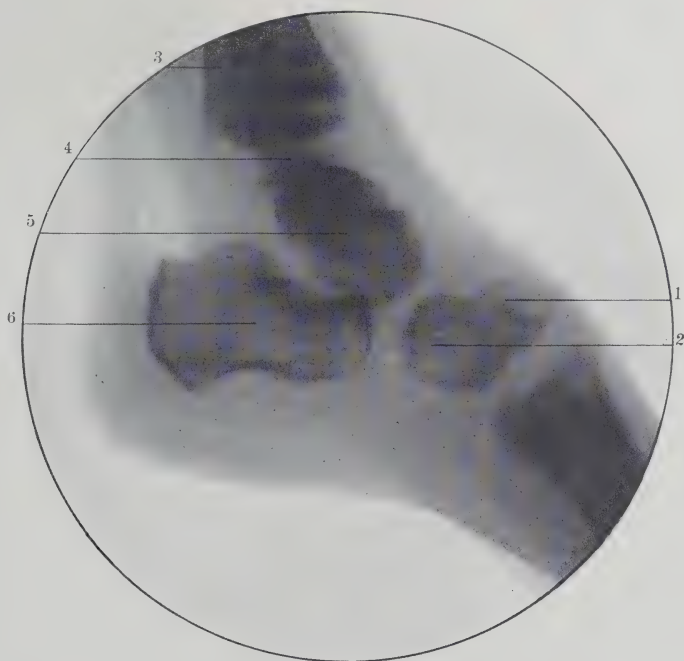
Radiograph Showing Lateral View of a Cretin's Foot at Twelve Years. 1, Scaphoid; 2, cuboid; 3, tibia; 4, fibula; 5, astragalus; 6, os calcis. (Original.)
